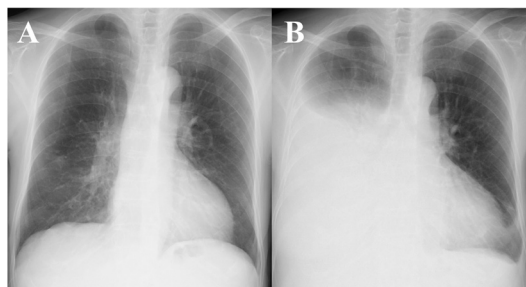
Chest radiography. (A) There was no pleural effusion before the initiation of peritoneal dialysis (PD). (B) A massive right pleural effusion shifting the mediastinum was detected 10 days after the initiation of PD.
